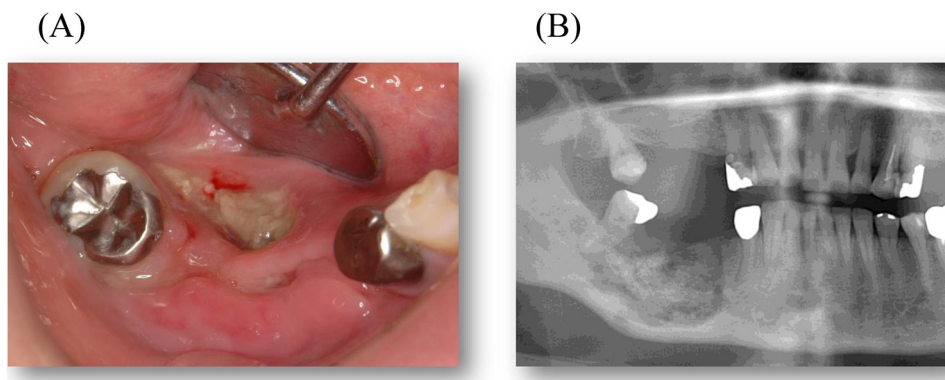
(A) Typical BRONJ with exposure of the jawbone. (B) Orthopantomogram showing separation of the sequestrum. BRONJ: bisphosphonate-related osteonecrosis of the jaw.
